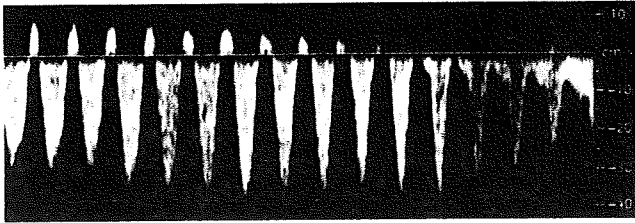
Typical image of intermittent AREFD in the umbilical artery Doppler waveforms, with cycles intermittently showing AREFD.
